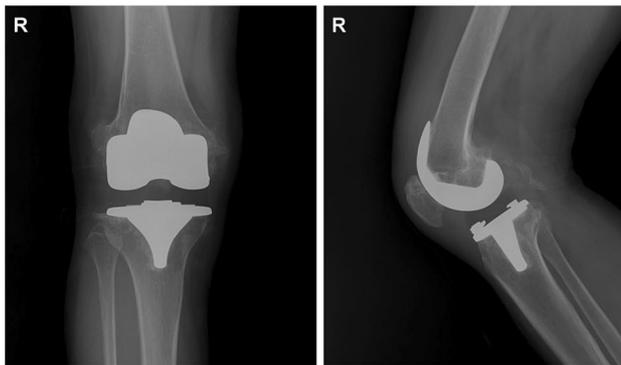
AP and lateral radiograph post-reduction, showing a reduced TKA
